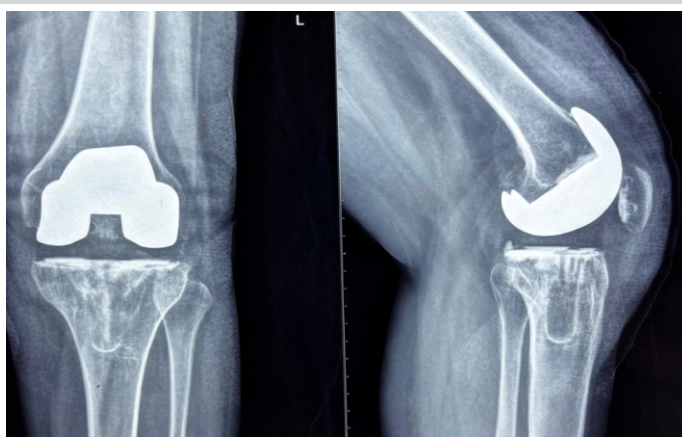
One-year follow-up radiographs demonstrating well-fixed total knee prosthesis with no evidence of residual or recurrent loose bodies or implant loosening.
